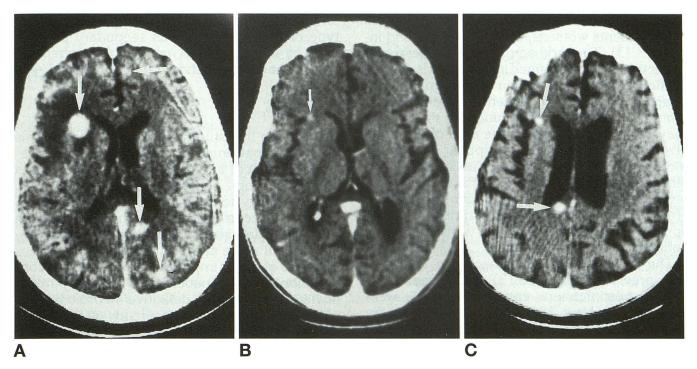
A*, CT exhibits four nodular toxoplasmosis abscesses of different sizes, one at the anteriormost part of right external capsule, two in the left occipital lobe, and one in the left frontal lobe (*large white arrows*).
